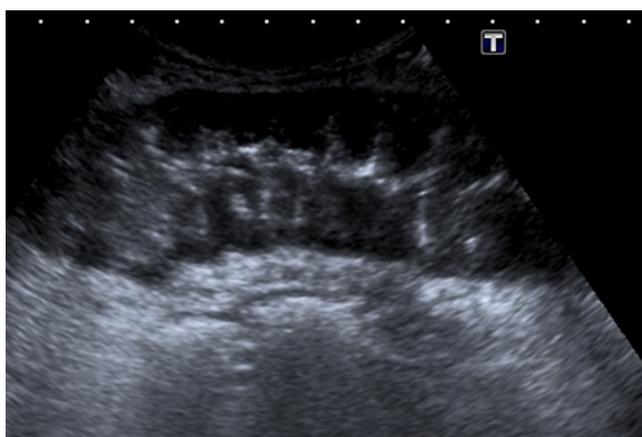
Abdominal ultrasound showed a marked thickening, edema and inflammation of the loops of the small and large intestines, with finger-like impressions.
